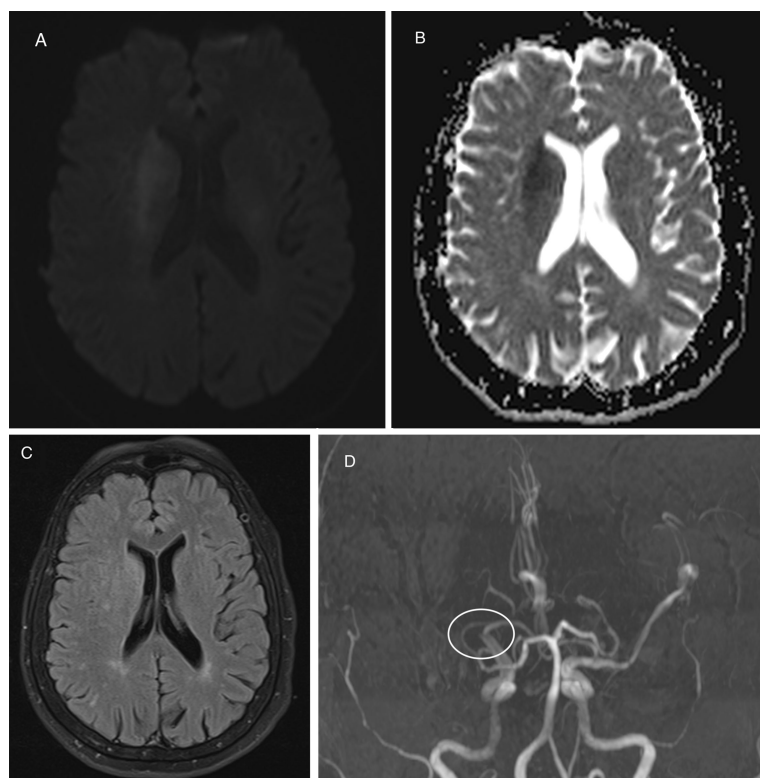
(A) DWI MRI b1000 sequence showing hyperintensity in keeping with hyperacute infarct, at the right MCA territory. (B) The corresponding ADC MRI sequence showing hypointensity at the same region, which confirms a hyperacute infarct. (C) The FLAIR sequence showing no signal changes at the affected region, in keeping with evidence of DWI-FLAIR mismatch. (D) The MRA sequence shows truncation of the proximal right MCA vessel, in keeping with MCA occlusion/large vessel occlusion (white circle). ADC, apparent diffusion coefficient; DWI, diffusion-weighted imaging; FLAIR, fluid-attenuated inversion recovery; MCA, middle cerebral artery; MRI, magnetic resonance imaging.
